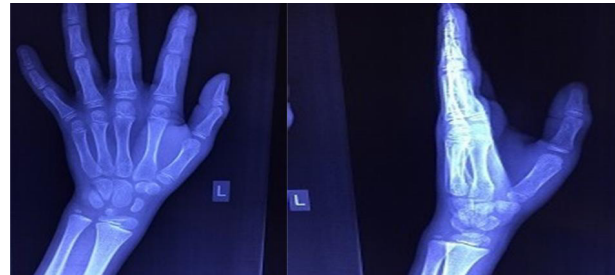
Post reduction radiograph showing congruently reduced MCP joint
